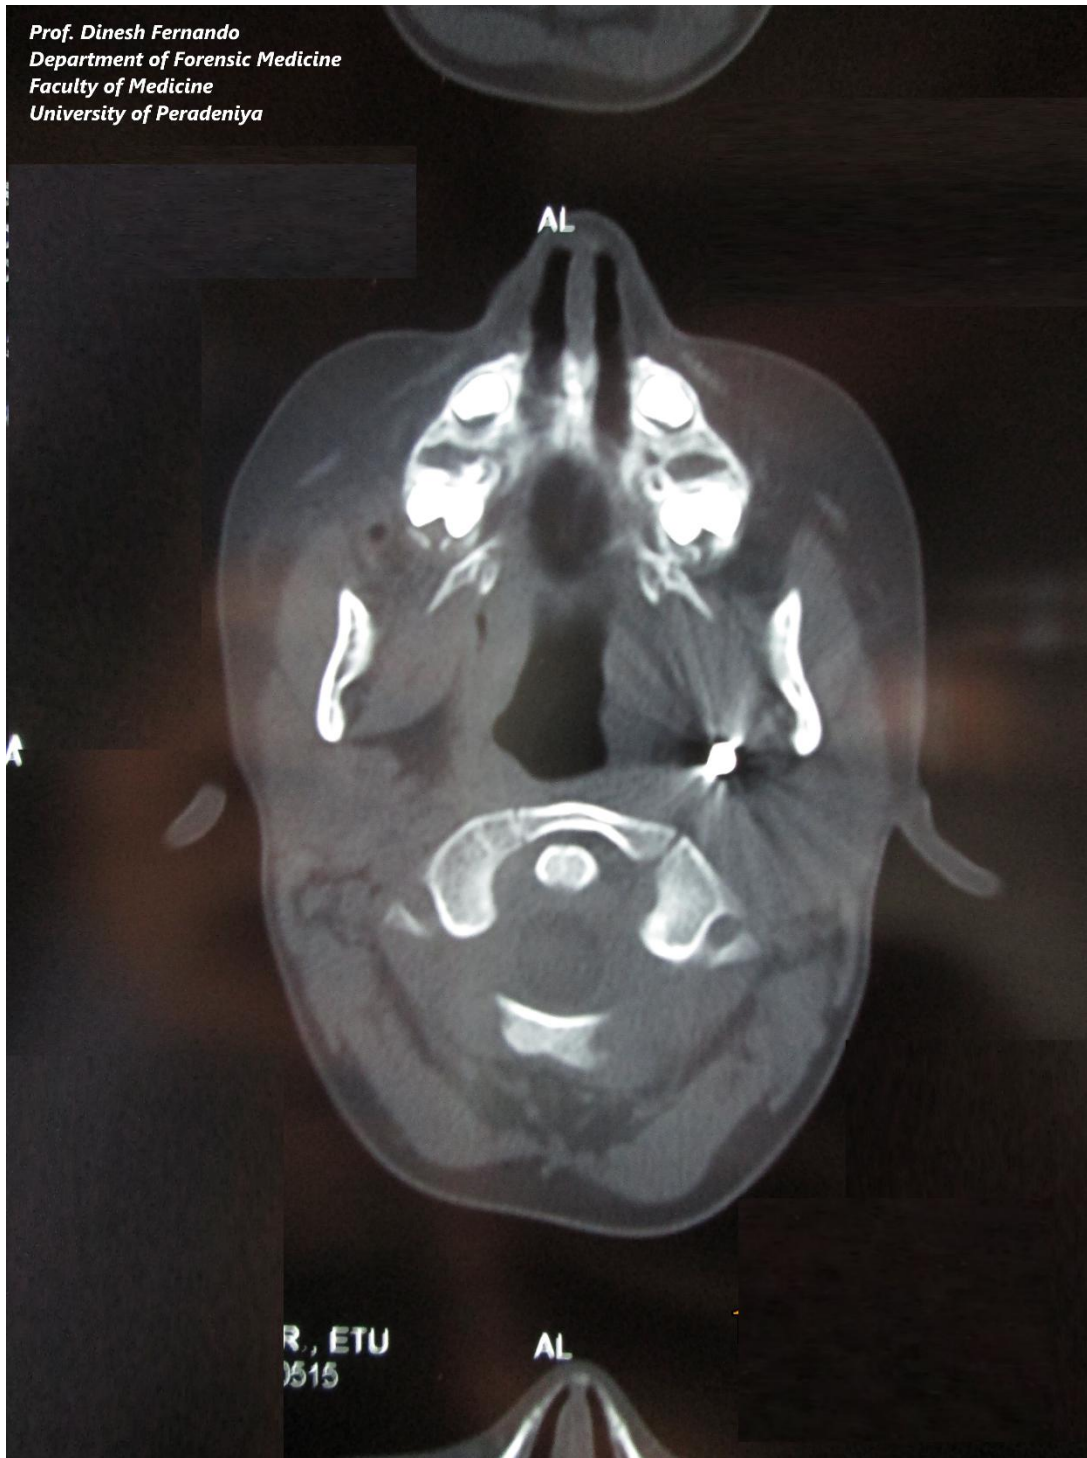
CT scan of the skull demonstrating a hyperdense object in the left pharyngeal space.
